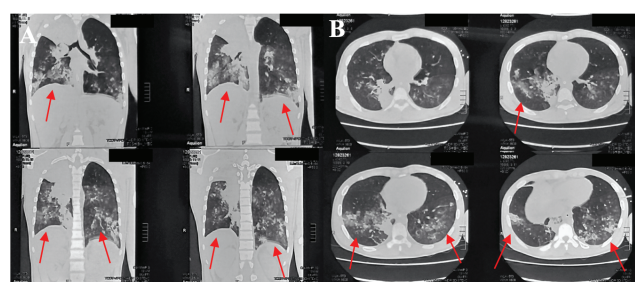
Thorax CT Scan showing bilateral “ground glass opacity” in the lung (arrow) in the coronal (A) and axial view (B).
